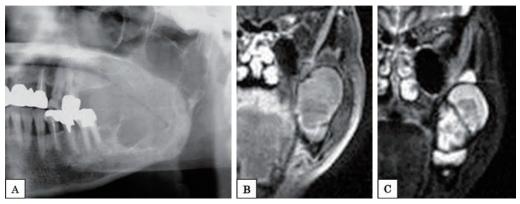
Aneurysmal bone cyst. (A) Multilocular radiolucent lesion in the ramus of the mandible. (B) T1-weighed MR image. (C) STIR MR image. Fluid-fluid level is seen in lesional cavities.
